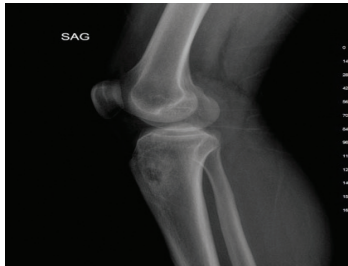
Preoperative lateral x-ray of the knee of the patient.
